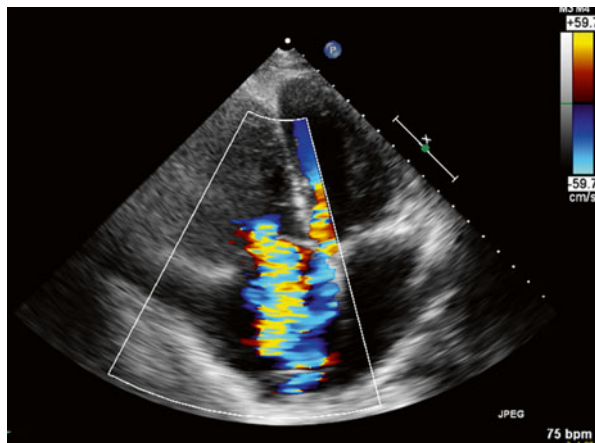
Echocardiogram. Echocardiogram (apical 4 chamber view) shows an enlarged right ventricle with significant tricuspid regurgitation
